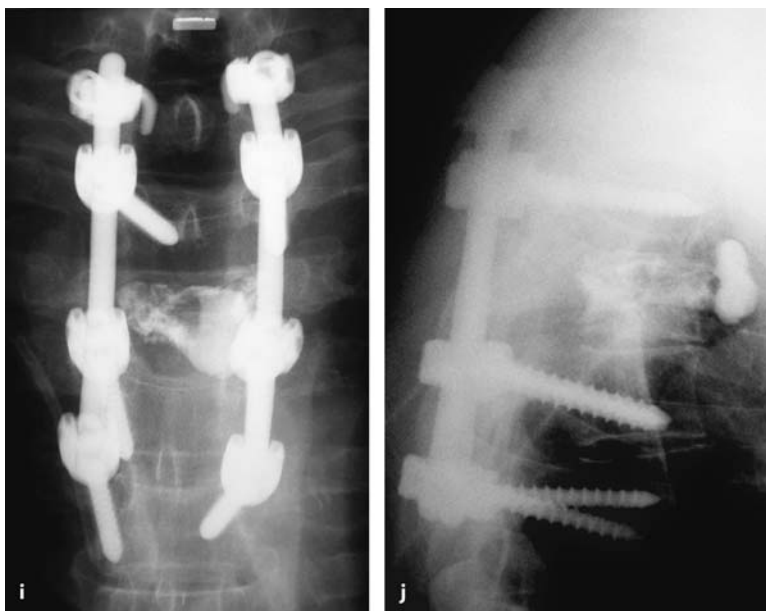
This is underlined by the axial MRI (c) and bone-window CT images (d). Instead of a demanding anterior approach at this level, a posterior approach was chosen. e This intraoperative view demonstrates the situation after removal of the spinous process of Th3. After laminectomy (f), both
